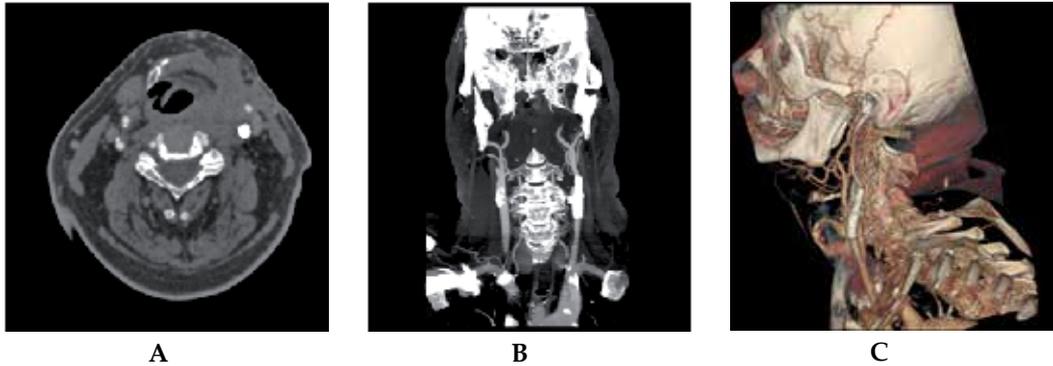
Initial CT scan confirming inflammation and pseudoaneurysm
